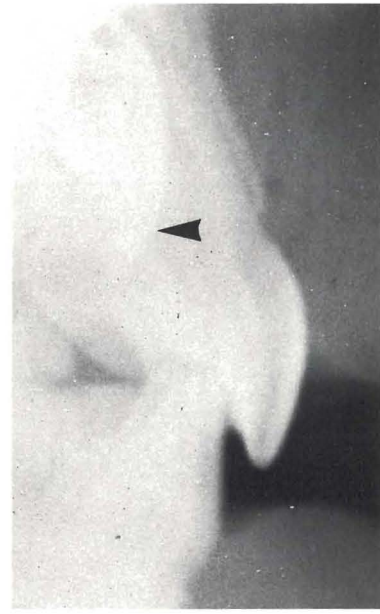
A lateral radiograph showing the anteroposterior and superior-inferior positions.
